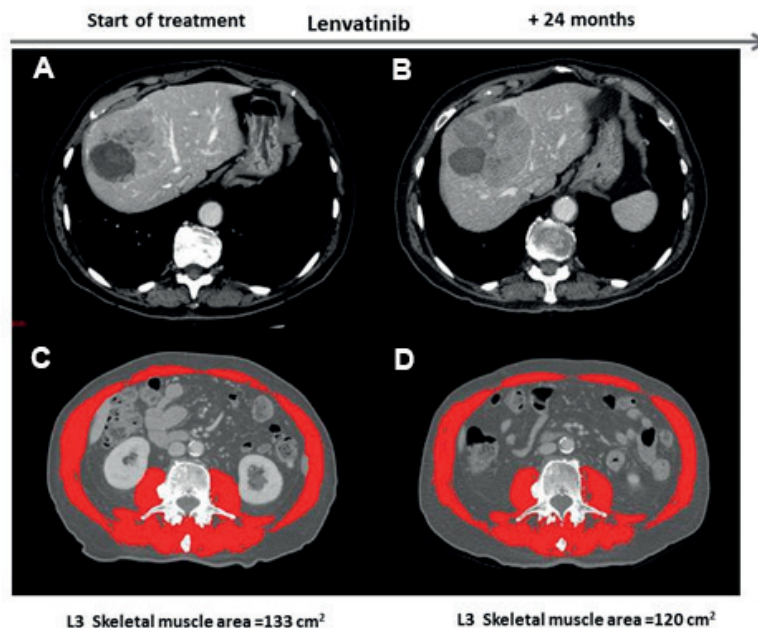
Skeletal muscle area (SMA) during chemotherapy with lenvatinib (Case 2). Panels A and B: CT scans of the liver at baseline (A) and at 24 months of chemotherapy (B) showing substantially stable disease. Panels C and D: CT scans of the skeletal muscle at the L3 level at baseline (C) and at 24 months of chemotherapy (D).
